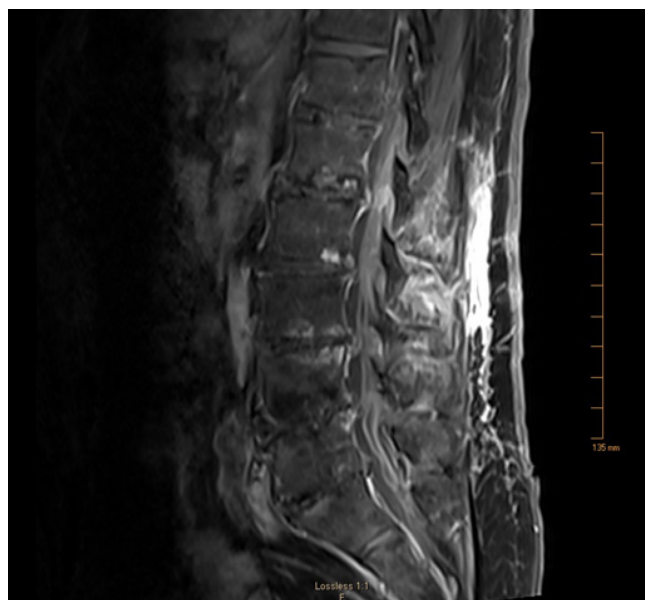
MRI Lumbar Spine with and without contrast, T1-Post contrast shows enlarged and enhancing nerve roots involving L1 through S1.
